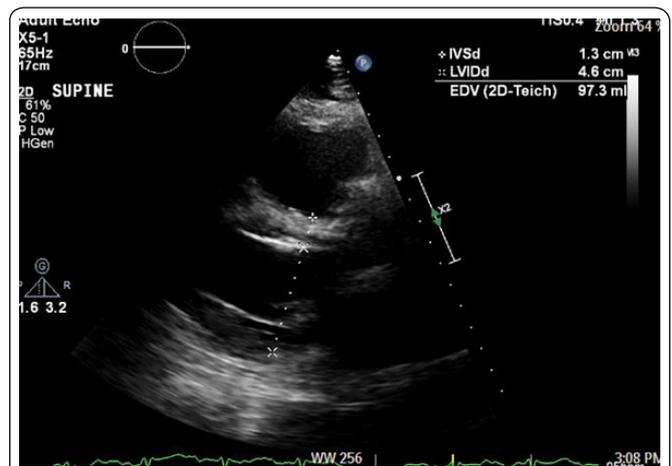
Post-drainage echocardiogram with improved LVIDd (parasternal long-axis view).
